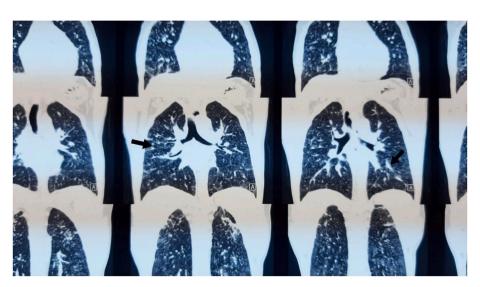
HRCT showing miliary mottled densities in both the lungs.
